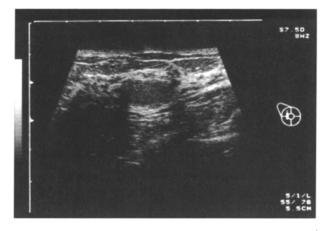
Ultrasonography shows a round, homogeneous, and hypoechoic mass with partially poorly-defined borders. Tumor measuring $1.7 \times 1.4 \times 0.8$ cm in diameter is imaged in the right breast. Images were obtained using SSA-250A with a 7.5 MHz annular array prove (Toshiba, Medical Systems, Tokyo, Japan)
